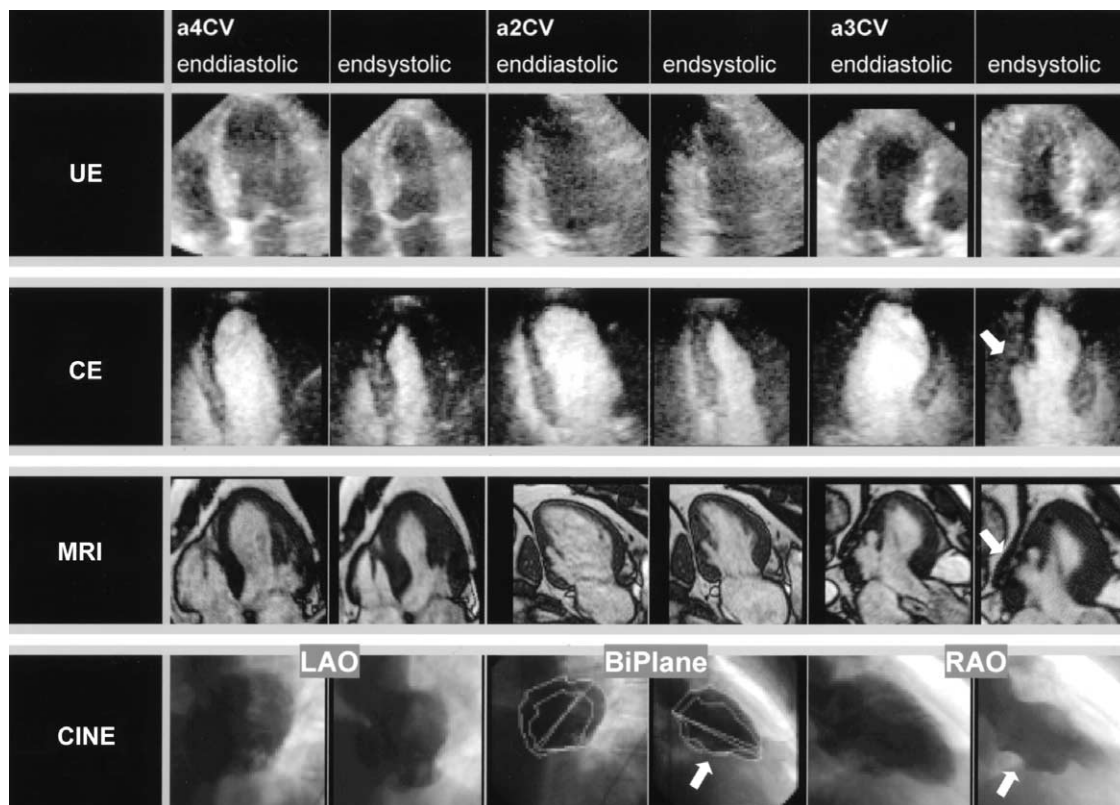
Multimodality comparison for regional wall motion abnormality in a 64-year-old patient with prior inferior myocardial infarction and occluded right coronary artery. Ejection fraction was normal (60%). There was concordance among magnetic resonance imaging (MRI), cineventriculography (CINE) and contrast-enhanced echocardiography (CE) in the detection of an inferior/posterior wall motion abnormality, which was not detected on unenhanced echocardiography (UE) owing to limited visualization of the inferior/posterior wall. LAO = left anterior oblique; RAO = right anterior oblique.
